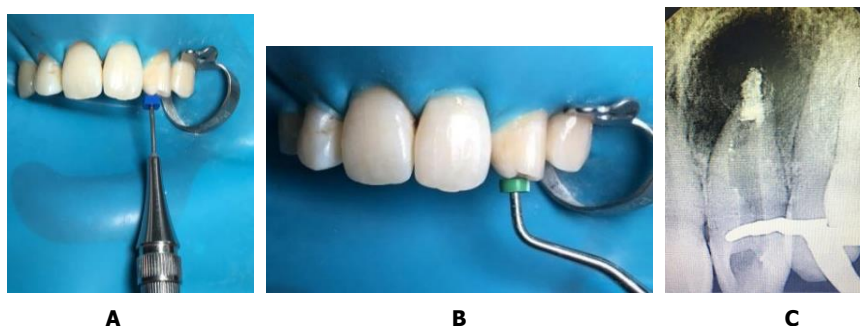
A. MTA application utilizing MTA carrier; B. MTA compacted with plugger; C. 4mm MTA application radiograph
